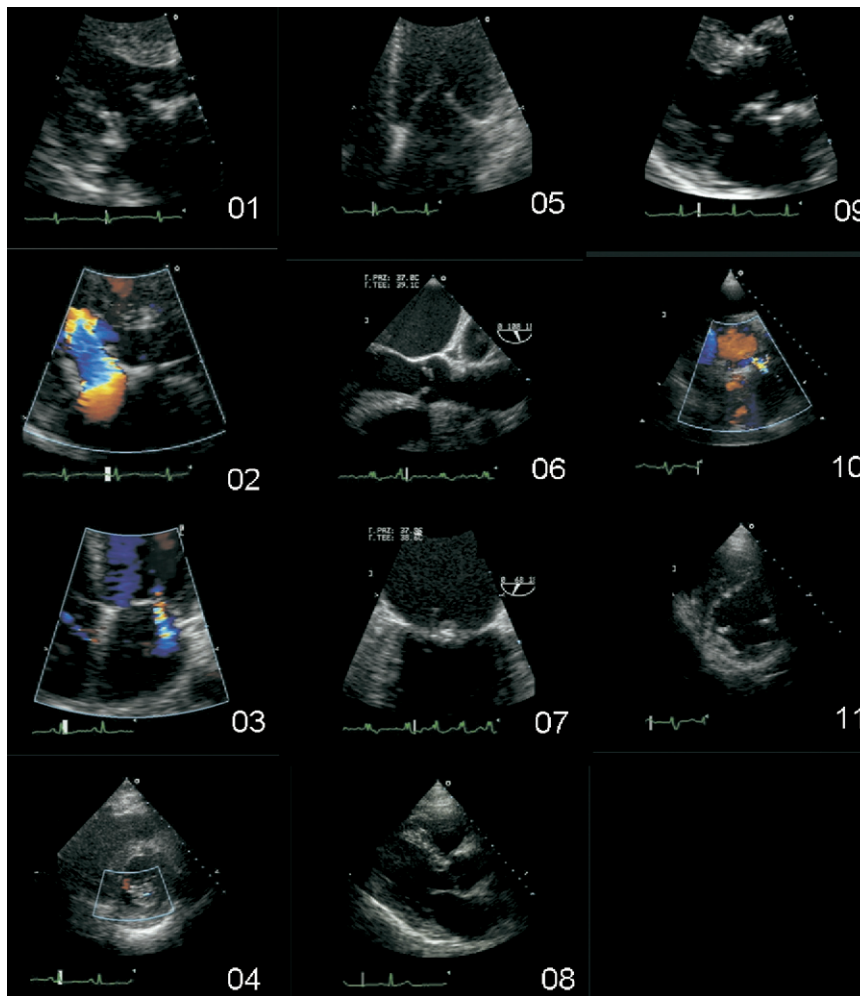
Original video files. *1*, Transthoracic (TT), 2-dimensional (2D), parasternal long-axis view (mitral valve level), normal mitral valve biologic prosthesis; *2*, TT, color Doppler, parasternal long-axis view, mitral valve biologic prosthesis; *3*, TT, color Doppler, apical 4-chamber view, mild mitral valve regurgitation; *4*, TT, color Doppler, parasternal short-axis view (mitral valve level), mild mitral valve regurgitation; *5*, TT, 2D, apical 4-chamber view, mild mitral valve stenosis; *6*, Transesophageal, 2D, upper esophageal long-axis view of aortic valve, mild aortic valve stenosis; *7*, Transesophageal, 2D, lower esophageal 2-chamber view, mitral valve vegetation; *8*, TT, 2D, parasternal long-axis view, normal myocardial and valvular structures; *9*, TT, 2D, parasternal long-axis view, mild mitral valve prolapse (posterior leaflet); *10*, TT, color Doppler, parasternal short-axis view (mitral valve level), mitral mitral paraprosthetic valve regurgitation; *11*, TT, 2D, parasternal short-axis view (papillary muscles level), ischemic dilated cardiomyopathy.
